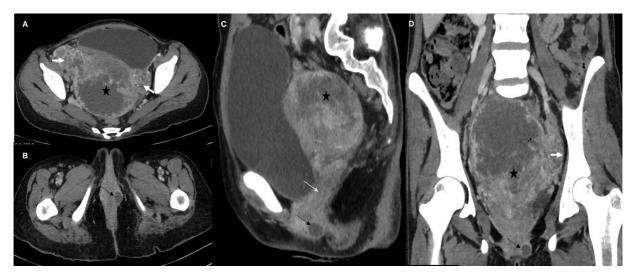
Stage II choriocarcinoma in a 34-year-old woman with contiquous extrauterine spread to adjacent genital tract. (A–D) Axial, sagittal, and coronal reconstructed contrast-enhanced computed tomography (CECT) images of the pelvis show enlarged uterus with large heterogeneously enhancing hypodense lesion ( $\bigstar$ ), enlarged ovaries in both adnexa (thick arrows), vaginal metastasis (white arrow), and a hypodense deposit in the vulva (black arrows).
